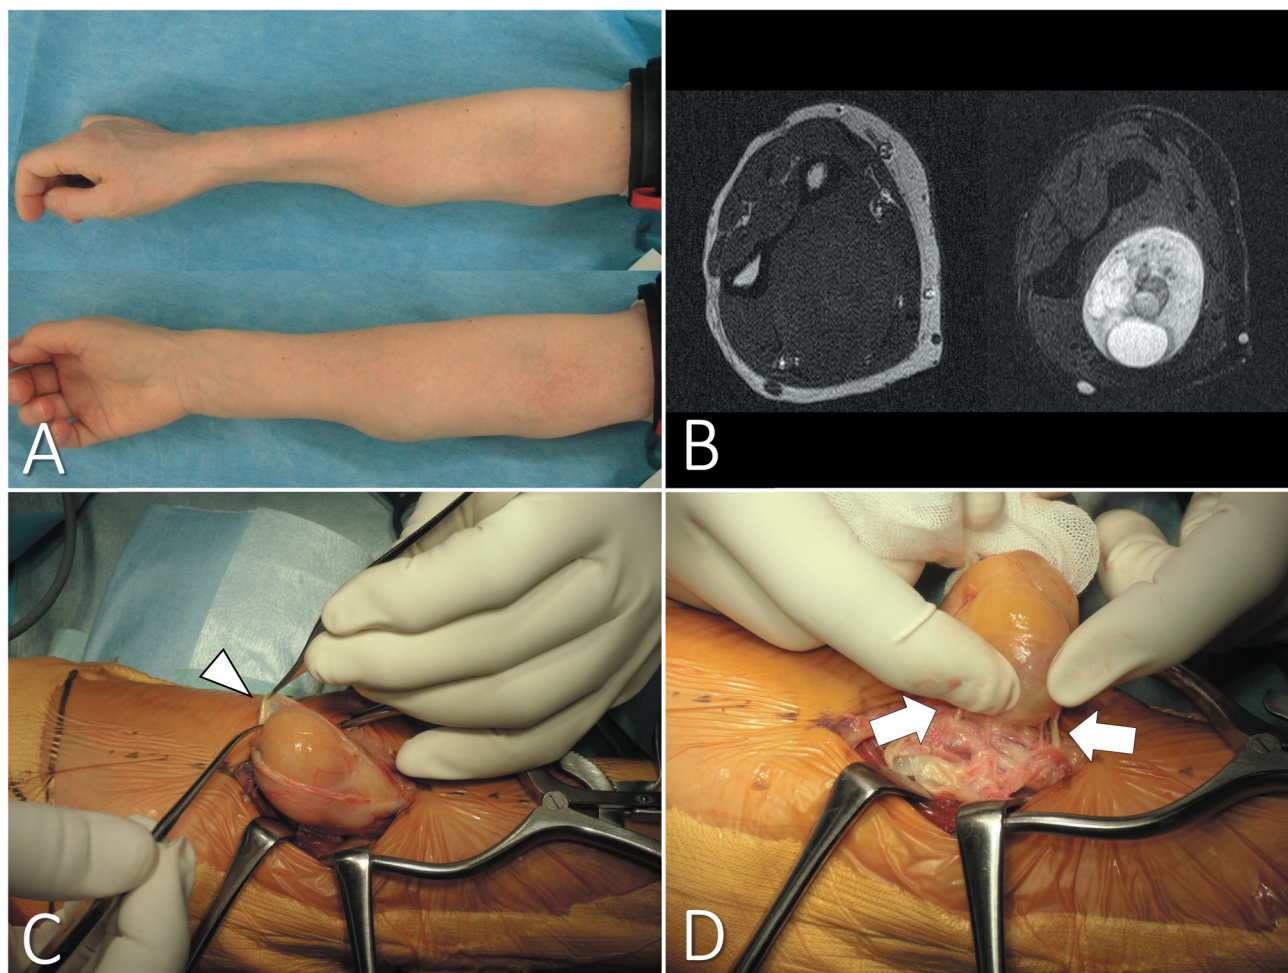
Clinical findings of schwannoma and surgical procedure. (A) A 66-year-old female with a mass on the right forearm. (B) MRI revealed a tumor in the forearm (left: T1 weighted image, right: T2 weighed image with fat suppression). (C, D) Open biopsy diagnosis was schwannoma, enucleation after the confirmation of nerve fibers by the neurostimulator. Arrowhead; capsule. Arrow; nerve fibers.
